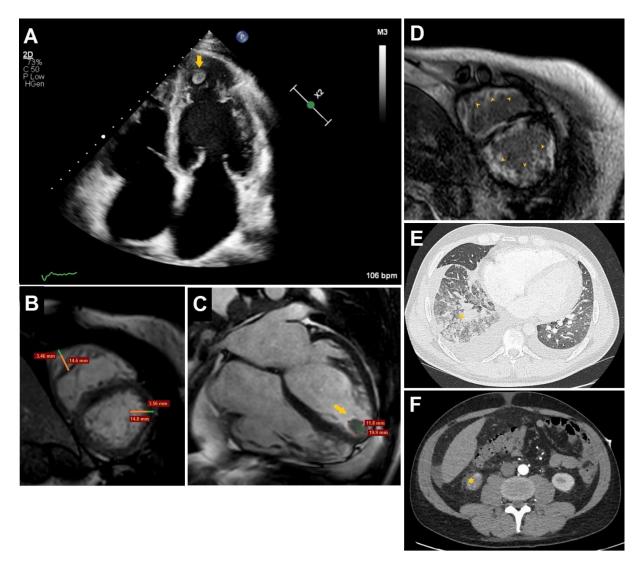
A. Transthoracic echocardiography in apical 4-chamber view showing LV hypertrabeculation and thrombus in the LV apex (arrow). B, C. CMR cinematographic sequences in short axis (B) and 4chamber (C) views showing non-compacted to compacted myocardium ratio for both ventricles and thrombus in the LV apex (arrow). D. CMR short tau inversion recovery sequence showing biventricular endocardial circumferential late gadolinium enhancement (arrowheads). E. High resolution computed tomography viewed in lung window with mixed lesions in the right lower lobe typical for infarction and pneumonia coexistence (asterisk). F. Contrast-enhanced computed tomography reveals a hypodense lesion in the right kidney's lower pole related to the infarction area (star) Abbreviations: CMR, cardiac magnetic resonance; LV, left ventricle
